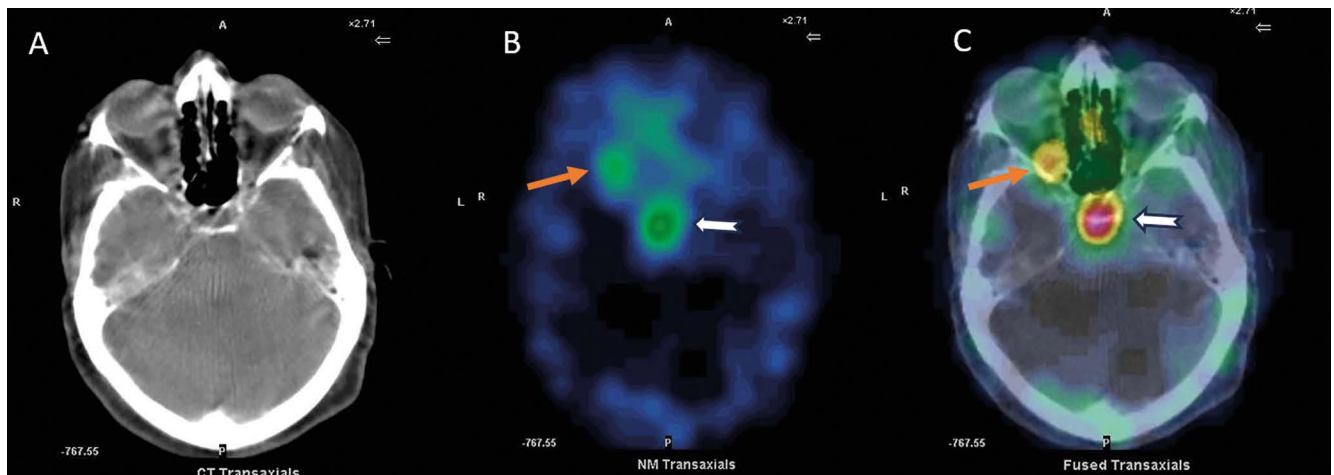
[^{99m}Tc]Tc-Tektrotyd scintigraphy: axial computed tomography image (A), axial SPECT image (B), axial SPECT/CT image (C). [^{99m}Tc]Tc-Tektrotyd scintigraphy corroborated focus of the right orbital with intense uptake, measuring 10 mm (orange arrow), corresponding to the lesion process described on brain magnetic resonance imaging. It shows also a physiological uptake of radiotracer in the pituitary (white arrow)
